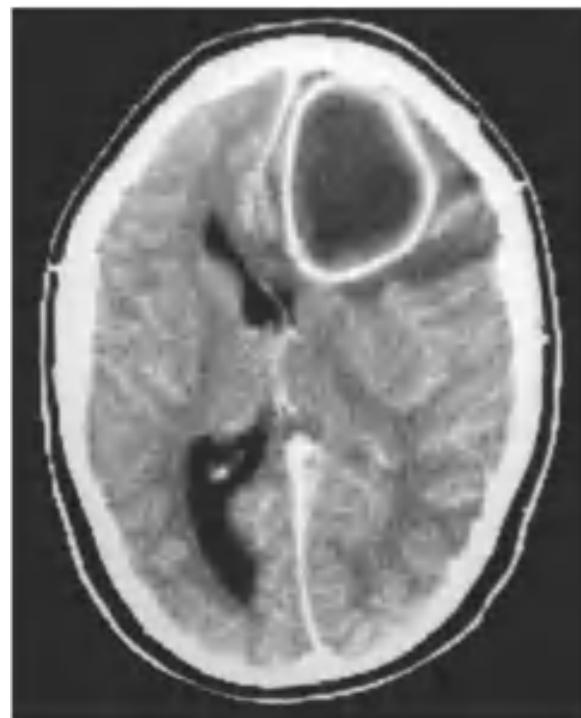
Brain abscess shown on CT with contrast. Note the large, wall-enhancing abscess in the left frontal lobe causing a rightward parenchymal shift. The patient had no neurologic signs until just before the CT scan, likely because the frontal lobe is a relatively "silent" area of the brain.
